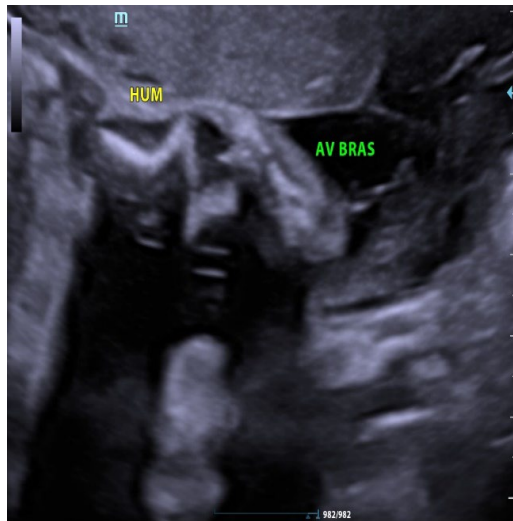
Sonographic appearance of a shortened upper limb.
